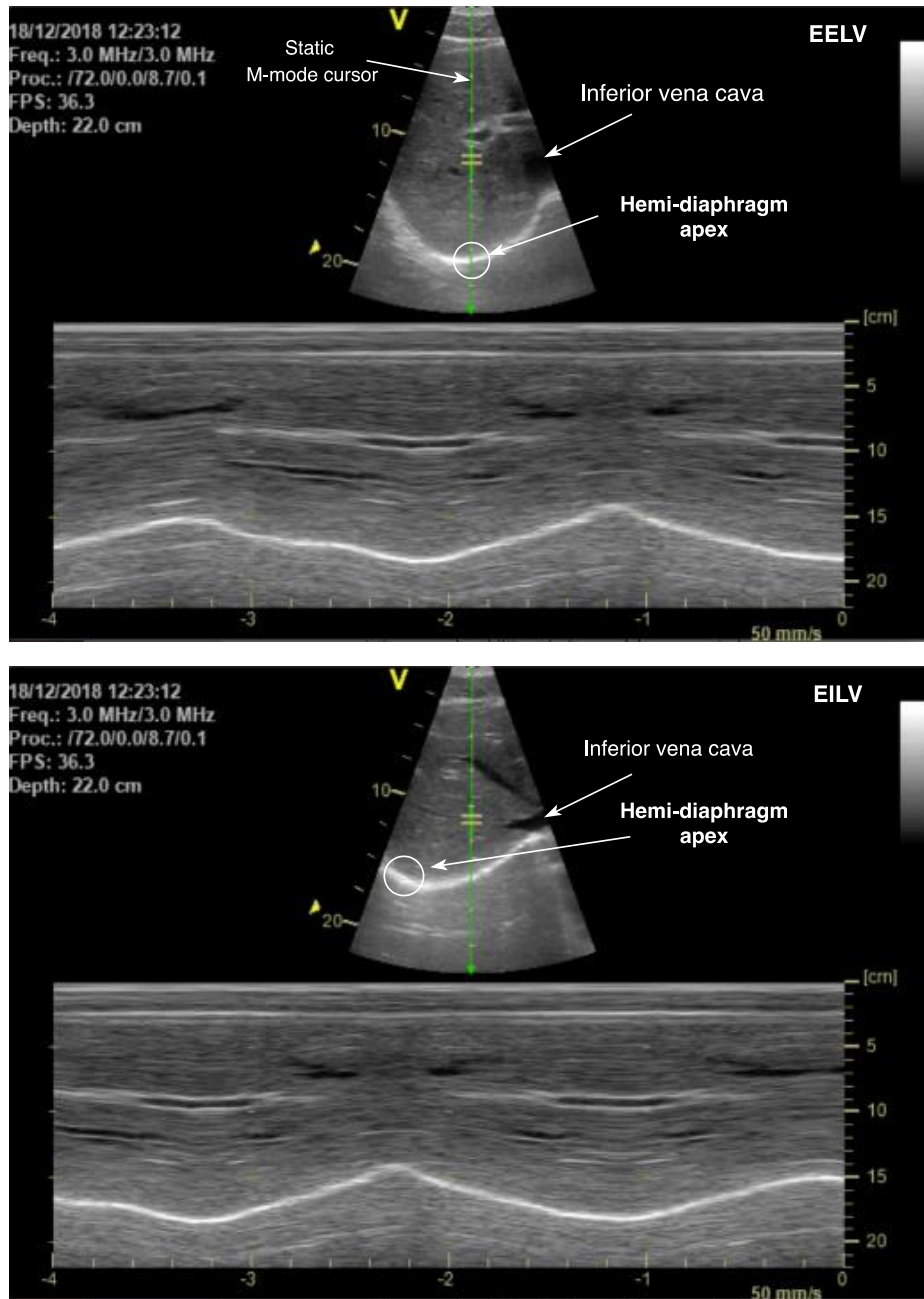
B-mode and M-mode ultrasound at EELV and EILV during hyperpnoea. The hemidiaphragm apex (indicated with white circle) moved diagonally away from the static cursor (green arrow), thus capturing excursion of the non-contractile central tendon rather than the contractile apex of hemidiaphragm dome.
